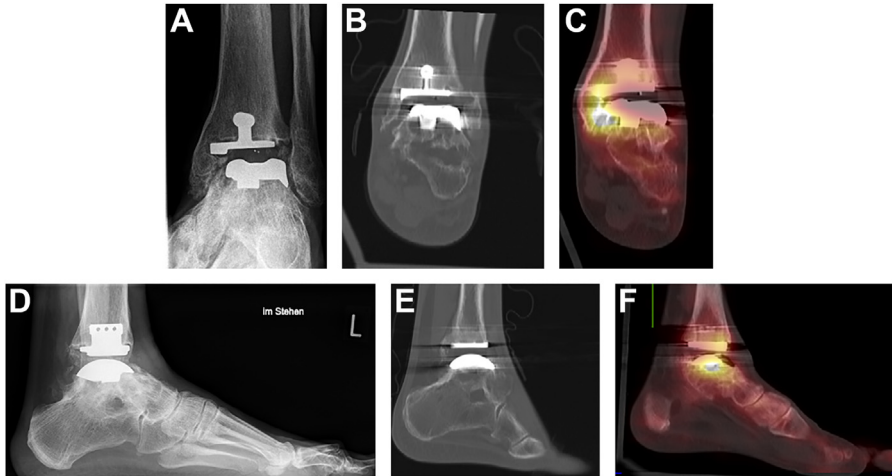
Talar cyst formation and subsequent prosthetic loosening after total ankle arthroplasty. A 50-year-old man presented in our clinic with acute pain 8 years after implantation of total ankle prosthesis (Tornier Salto) and subtalar arthrodesis. (A, D): Conventional radiographs showed tibial stress shielding without other abnormalities. (B, E): CT imaging reveals talar cyst formation. (C, F): To exclude prosthetic loosening, SPECT/CT was performed depicting high grade osteolysis with tracer enhancement presumably in talar bone (Fig. 1B, C, E, F). Acute pain was likely due to acute osteolytic fracture. Therapy options comprised cyst filling and revision of the talar component or arthrodesis of the ankle joint.
